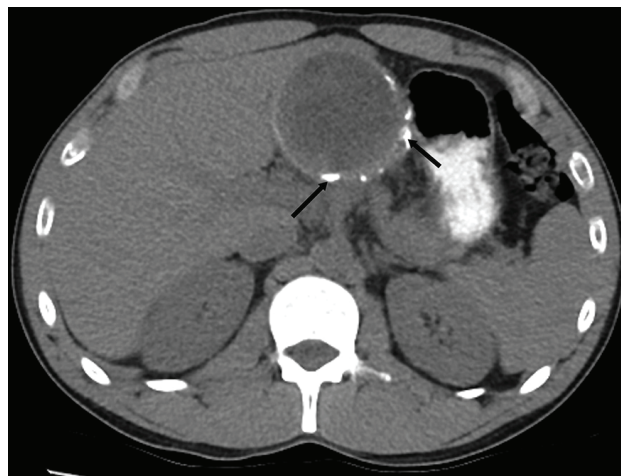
Axial, non-contrast enhanced abdominal CT scan shows a focal, hypodense rounded lesion of partially calcified margins (arrows) in segment II of the liver. Gharbi type IV-CE4.
